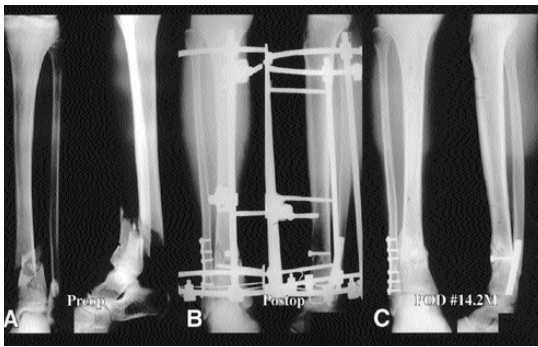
(A) The preoperative AP and lateral radiographs of 29-year-old man with a comminuted distal shaft tibiofibular fracture of Gustilo open type . (B) Immediate postoperative AP and lateral radiographs with hybrid external fixation(half pin, push pin, lag screw and AnyFixR). (C) At 4 weeks after operation, bone grafting without change of external fixator was done. The last follow up radiographs at 14.2 months show good union.
